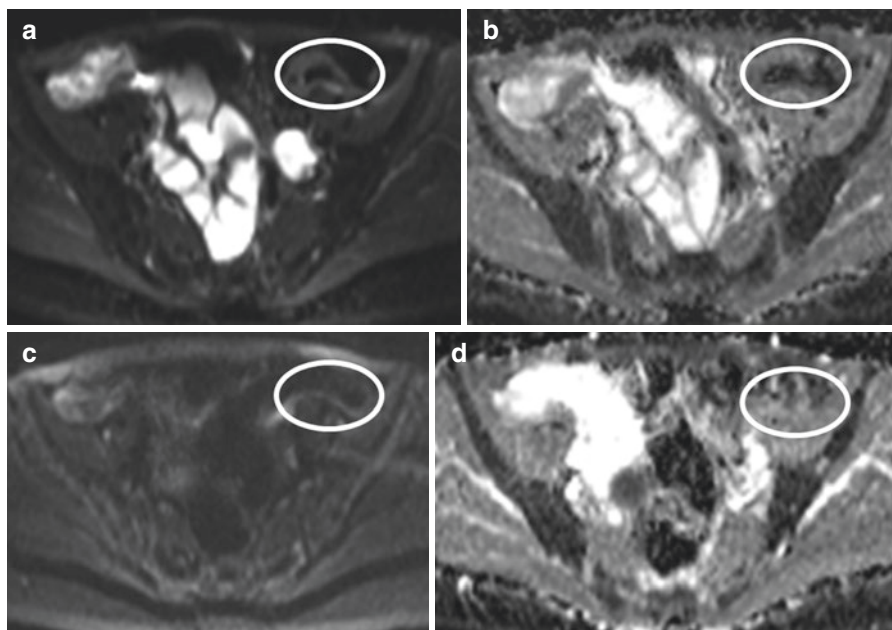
(a) DWI ($b = 800$) shows high signal intensity in a proximal sigmoid tract with correspondent ADC restriction (b). (c) Axial DWI ($b = 800$) shows no areas of high signal intensity with no restriction in the ADC map (d) after therapy
